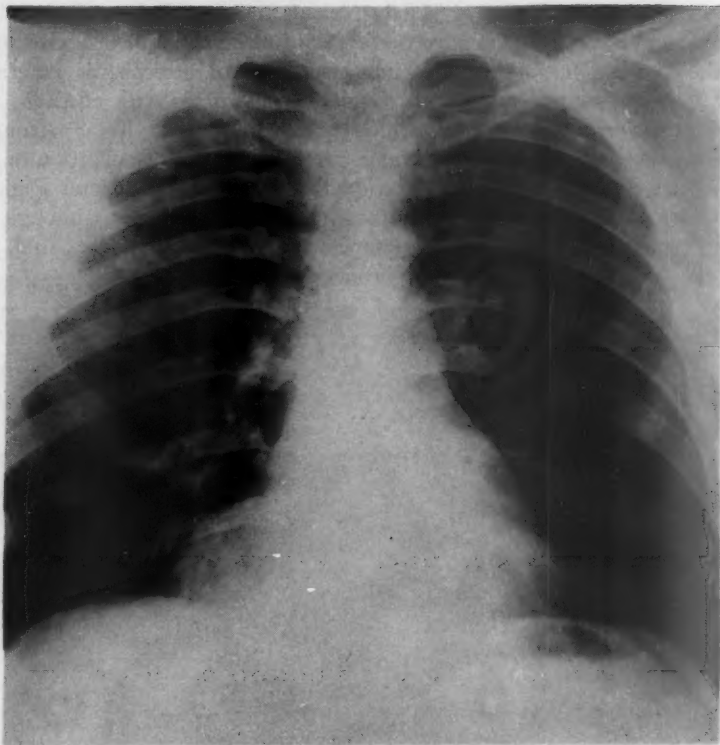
This 22 year old white male was referred to the hospital because of an abnormality found on his chest roentgenogram. The posterior-anterior chest roentgenogram shows the density to be present in the right cardiophrenic region. No symptoms and no positive findings were present on physical examination.
